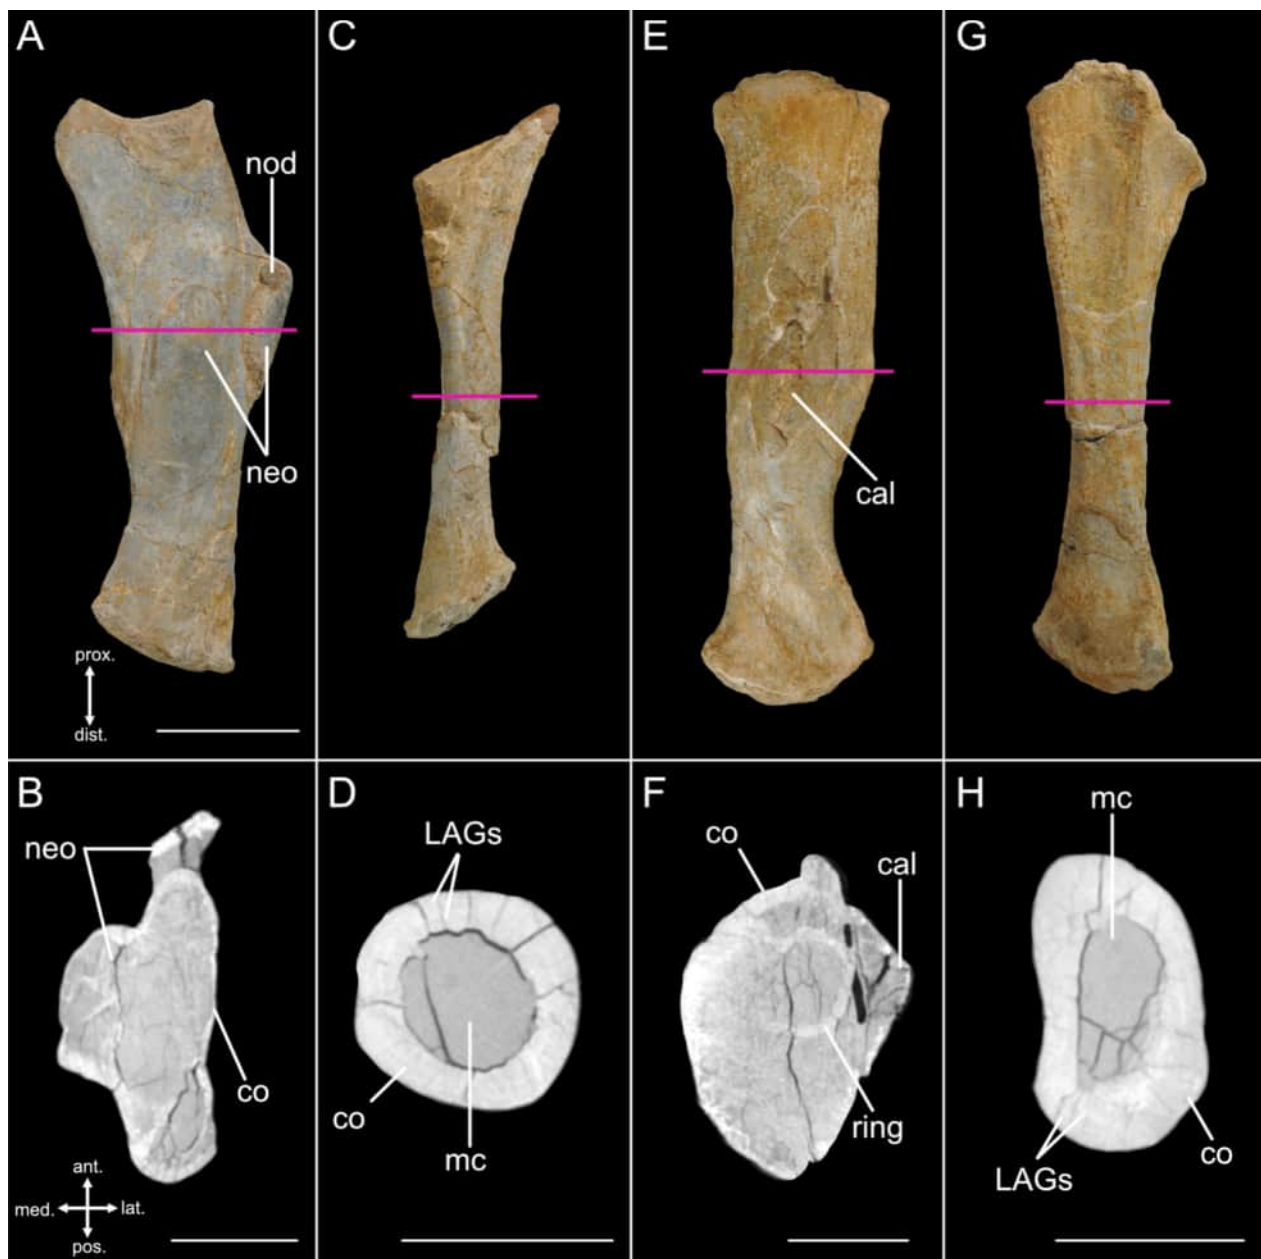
Radii and ulnae, and CT cross-sections of these bones, of *Plateosaurus trossingensis* SMF 11.4. A left radius 11.4.144 in medial view and B cross-section of the radius at the mid-shaft with its location indicated by the pink line in A. C right radius 11.4 in medial view. D cross-section of the radius at the mid-shaft with its location indicated by the pink line in C. E left ulna 11.4.189 in lateral view. F cross-section of the ulna at the mid-shaft with its location indicated by the pink line in E. G right ulna 11.4 in lateral view. H cross-section of the ulna at the mid-shaft with its location indicated by the pink line in F. Same orientations for B, D, F and H. *ant* anterior, *cal* callus, *co* cortical bone, *dist* distal, *LAGs* lines of arrested growth, *lat* lateral, *med* medial, *mr* medullary region, *neo* potential neoplasm, *nod* bony nodule, *pos* posterior, *prox* proximal, *ring* internal ring of bone. Scale bars 50 mm (A, C, E, G) and 20 mm (B, D, F, H)
